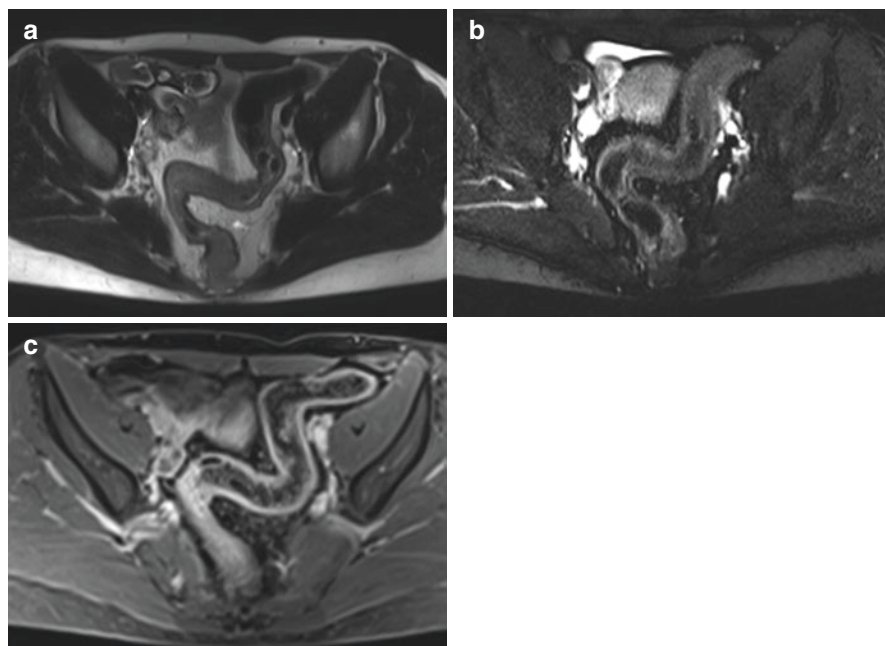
(a) T2-W sequence shows rectal and sigmoid wall thickening in patient with CD. (b) T2-W FS shows submucosal mild edema. (c) T1-W sequence after Gd administration shows mild mucosal enhancement in the late phase. MRI findings suggest fibrotic evolution
